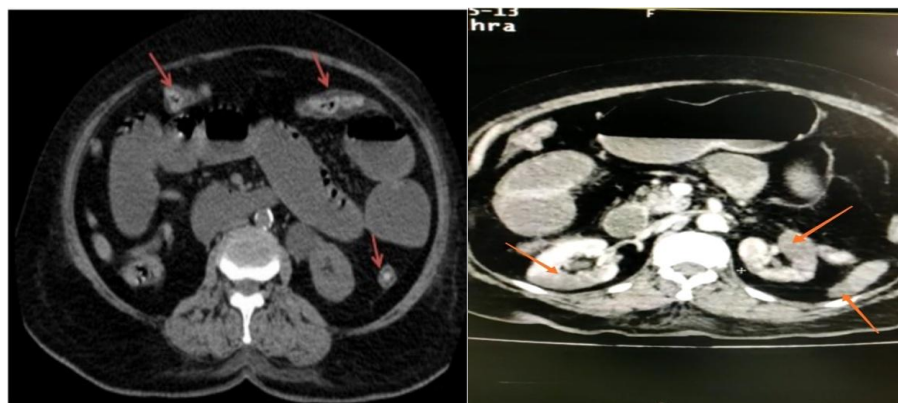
Axial CT scan with no injection shows pan colitis on the left and splenic and renal infarctions on the right
